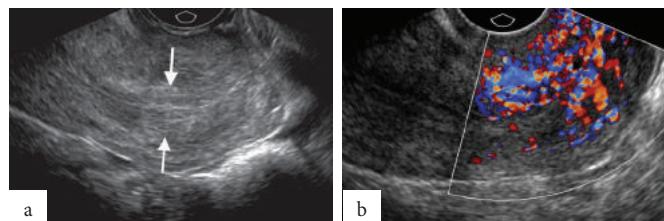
Sagittal US scans in a case of cervicitis showing heterogeneity of the mucosal layer (arrows in a) with marked hypervascularity on colour Doppler US (b).
